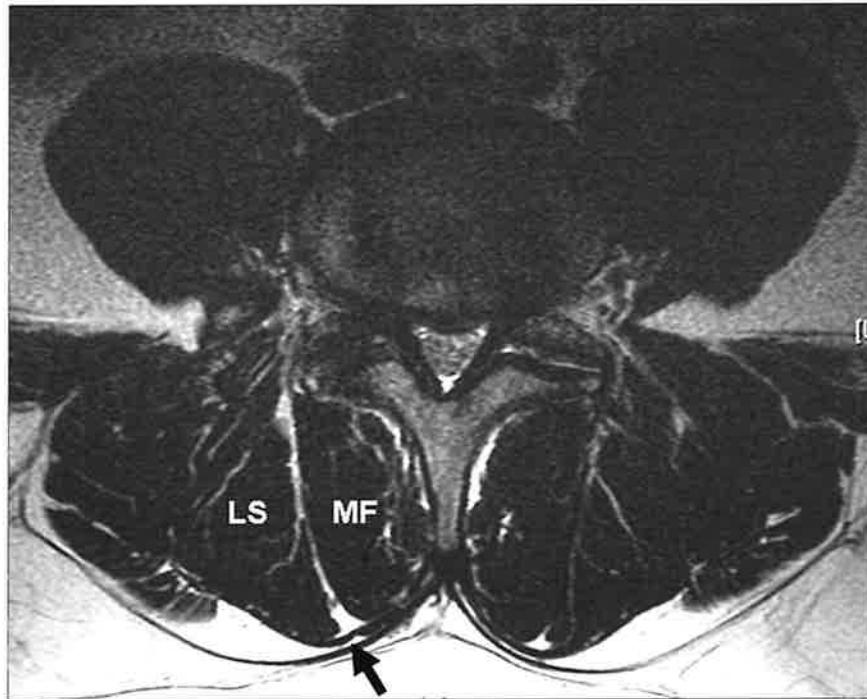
Magnetic resonance image (MRI) of lumbar paraspinal musculature, multifidus (MF) and longissimus (LS) (54).
